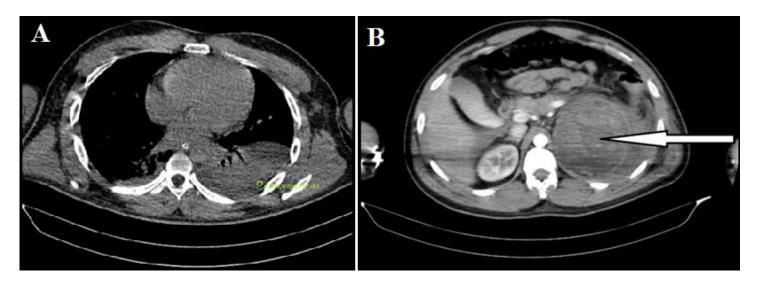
A) computed tomography showing bilateral pleural effusion with high attenuation 51HU; B) computed tomography showing heterogenous mass lesion in the left supra renal region marked by white arrow
